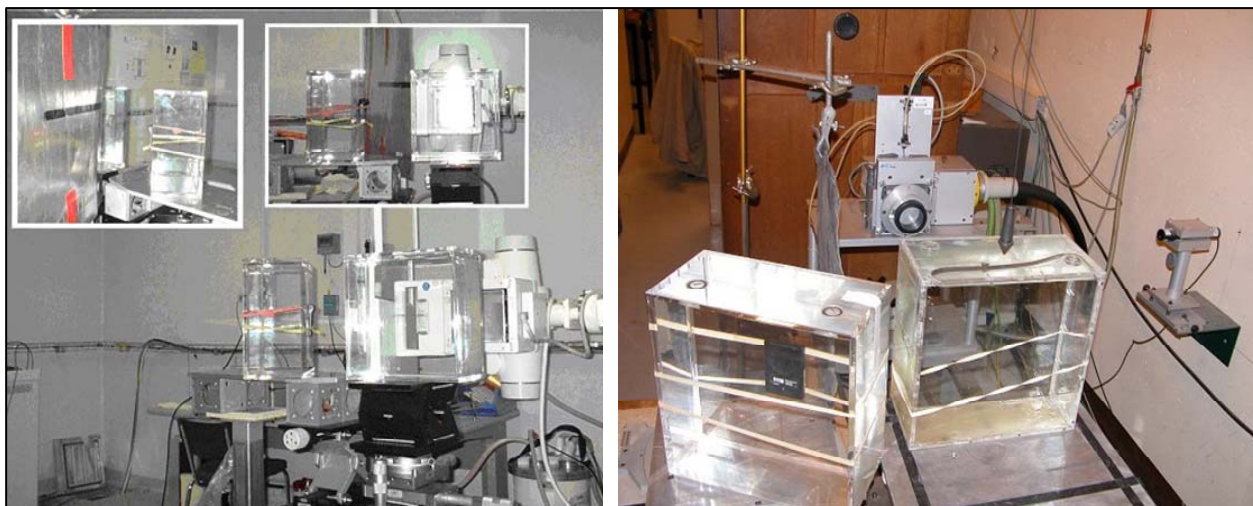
Experimental set up using the pulsed X-ray facility (left) and the continuous X-ray facility (right).
